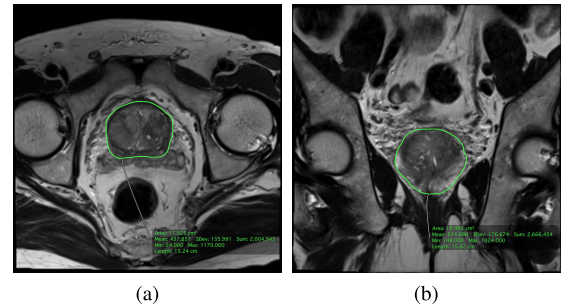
2D prostate T2W MRI (a) axial view, (b) coronal view. The prostate boundary is marked by the green line.
